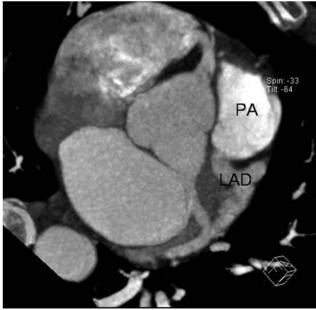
Coronary CT angiography showing the origins of the three coronary arteries. The circumflex and right coronary arteries originate from the left and right sinuses of Valsalva respectively, whereas the left anterior descending (LAD) artery originates from the pulmonary artery (PA).
